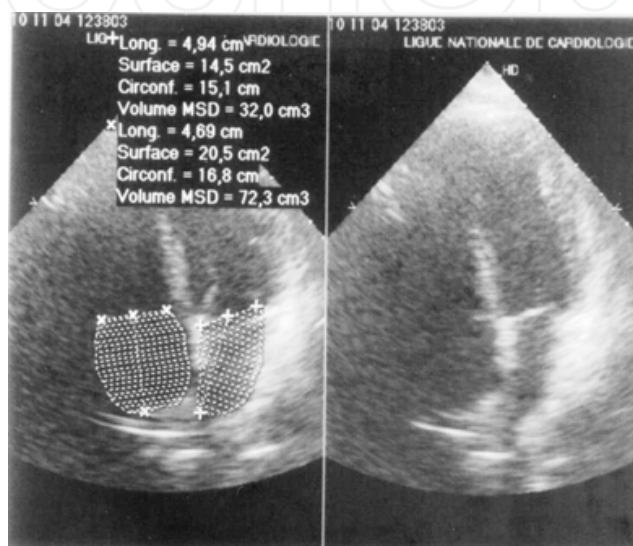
Echocardiography parasternal long axis depicted improvement of ventricle function. Echocardiogram obtained at admission depicts global hypokinesis with left ventricle ejection fraction (LVEF) of 40% and important dilation of right ventricle and auricle.
